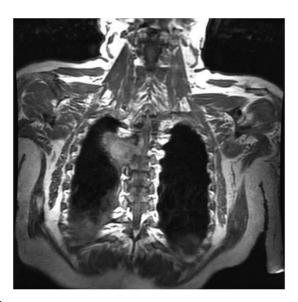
MRI lung cell carcinoma.
